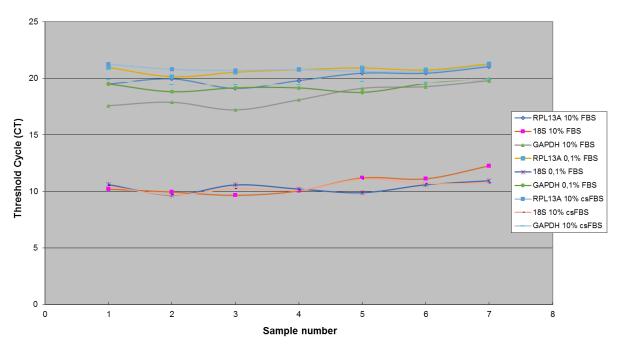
CT values of HKGs under E2 stimuli. Stability of HKGs' expression in cells cultured in different media and under stimuli with increased concentrations of E2.
